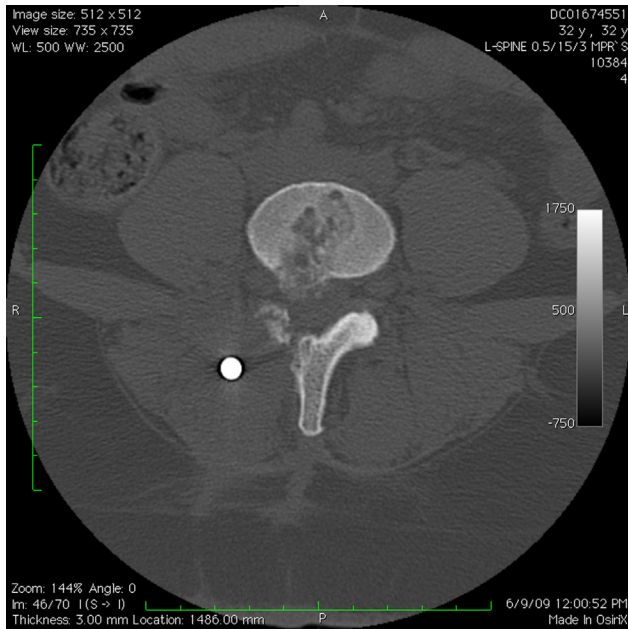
Axial computed tomography image (Top) demonstrating right neuroforaminal bone growth at L4/L5. (Middle) An intraoperative image with the exiting nerve root retracted superiorly revealing the ventral surface bone growth. (Bottom) Intraoperative imaging revealing the ventral surface bone growth resected and the exiting nerve root neurolysed.
